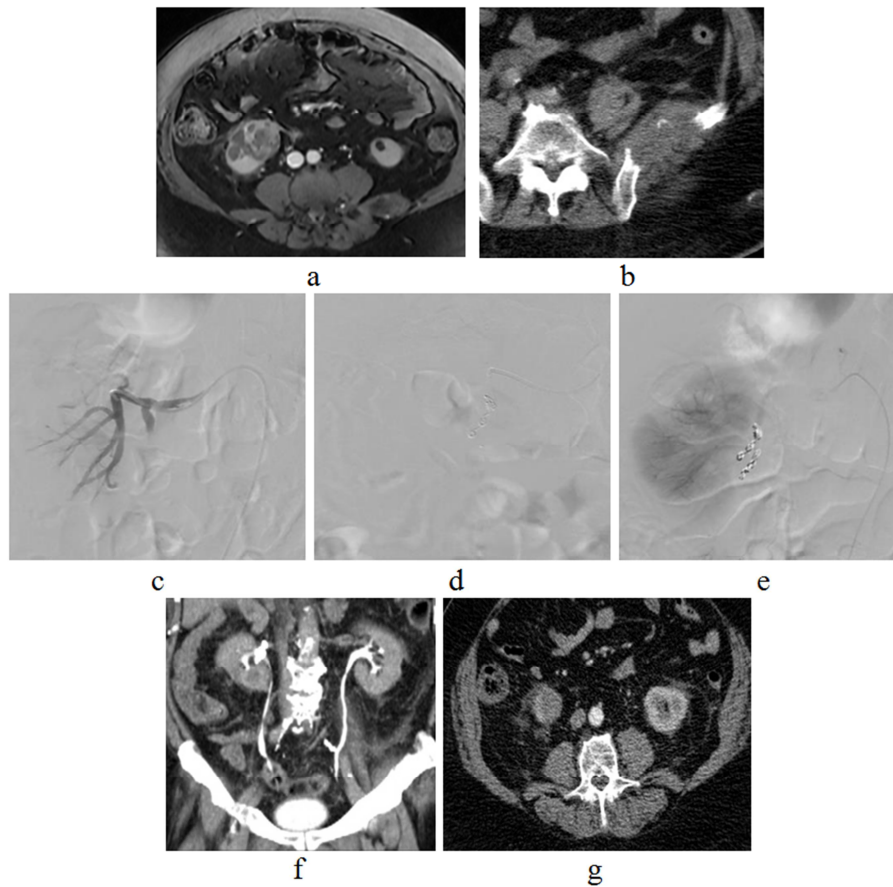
a, Post contrast Axial MRI images shows ill-defined enhanced lower pole right renal mass with infiltration of the perinephric fat planes, b: Axial CT image of the pelvis shows destructive left iliac metastatic soft tissue mass lesion. c, Selective catheterization of the feeding artery to lower polar mass using micro catheter. d, Selective embolization was done using two micro coils. e, Post embolization angiogram show no further opacification of the tumor with preservation of the remaining right renal vasculature. f, 1st Follow up post contrast CT coronal excretory phase after 1 month duration shows little enhancement of the mass with stranding and thickening of the perinephric fat and small peri nephric hematoma. j) 2nd Follow up by post contrast axial CT image after 3 month duration shows no significant enhancement of the lower polar mass with resolution of the perinephric hematoma.
